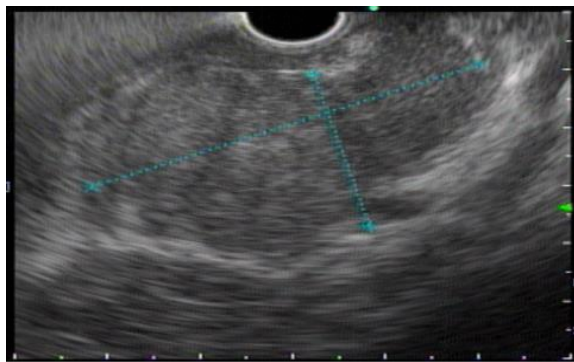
EUS ultrasound showed well defined mass measuring 3.5x 2.5cm in size in pancreas
